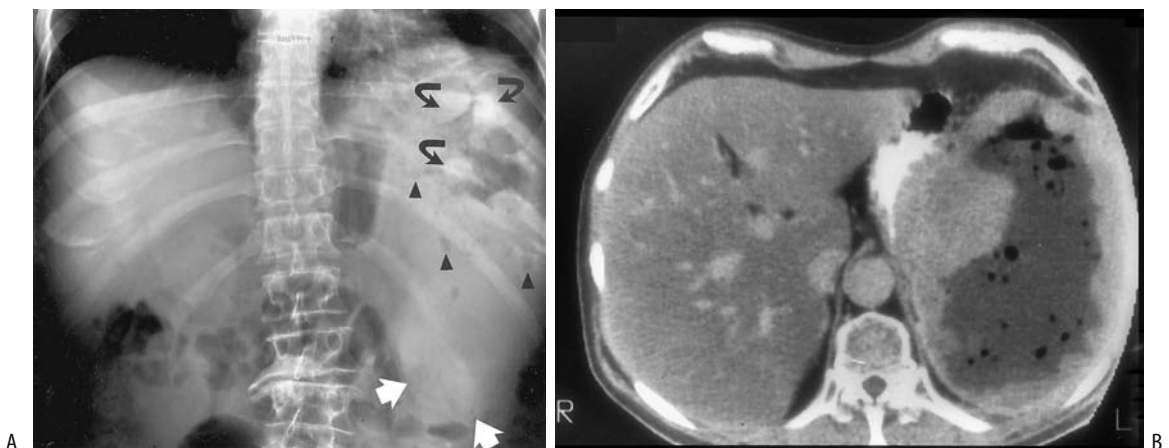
Splenic lymphoma. A: Splenomegaly is present (white arrows). Mottled gas (arrowheads) outlines nodules (curved arrows) in a necrotic cavity. B: The necrotic cavity is better identified on contrast-enhanced CT. A gas-fluid level is present in an irregular, nodular cavity. (Source: Dachman AH, Buck JL, Krishnan J, Aguilera NS, Buetow PC. Primary non-Hodgkin's splenic lymphoma. *Clin Radiol* 1998;53:137–142, with permission from the Royal College of Radiologists.)
